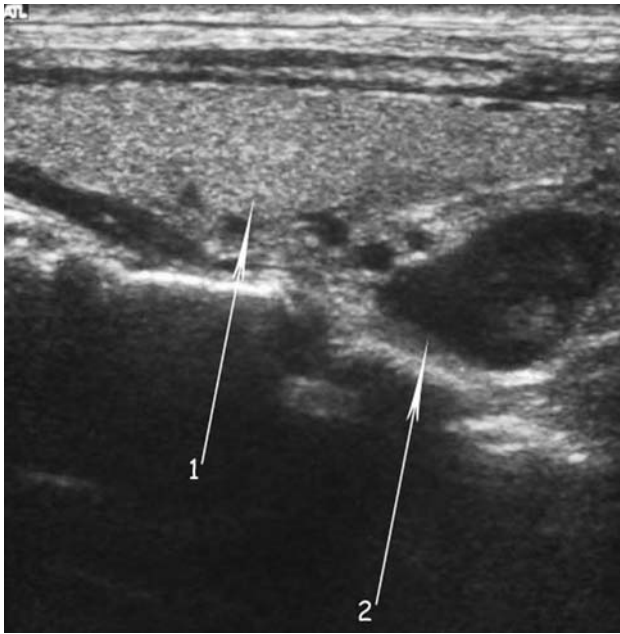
Ultrasonography. Arrow 1: Right thyroid lobe. Arrow 2: parathyroid adenoma posterior to the inferior pole of the thyroid lobe: position 2
